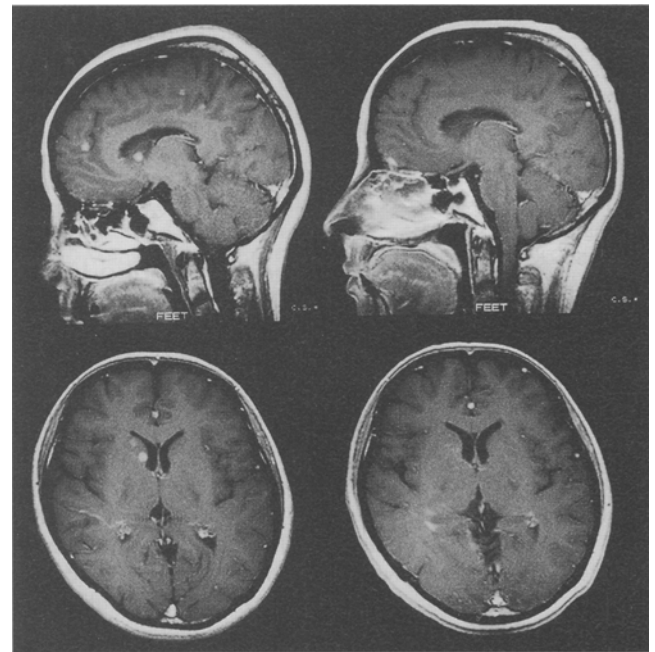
Magnetic resonance imaging of the brain of the patient described in Fig. 1, taken before whole brain irradiation. Multiple brain metastases are evident (left). After intracranial irradiation, these tumors are gone (right).
